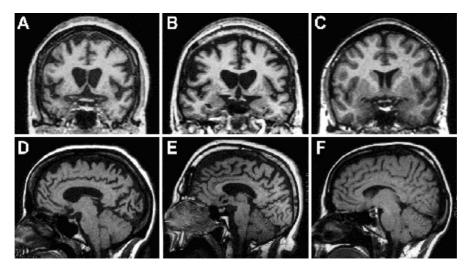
(A) and (D) MRI scans of an HDL2 case after 10 years disease duration. (B) and (E) MRI scans of HD brain after 12 years disease duration. (C) and (F) normal control at 43 years old [Taken from Margolis *et al.*, 2003].
